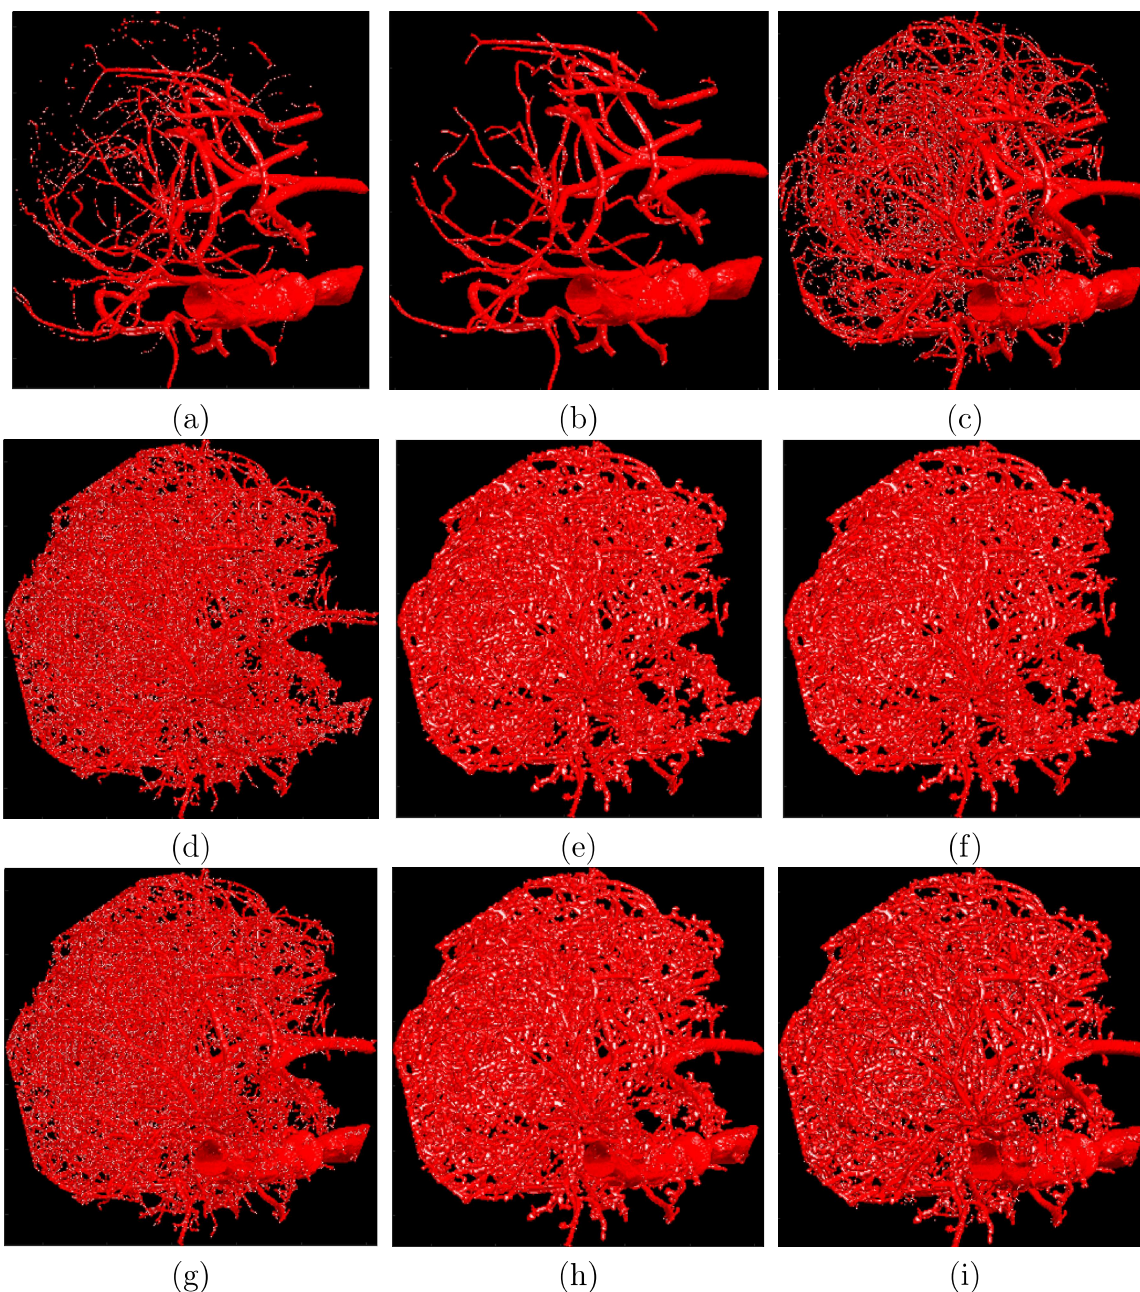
Visual comparison of the three developed hybrid segmentation methods on CT scan images. (a) medium to big vessels using multi-threshold Otsu method; (b) medium to big vessels using multi-threshold Otsu method combined with hysteresis thresholding; (c) medium to big vessels using hysteresis thresholding; (d) small to medium vessels using WHVEF in [37]; (e) and (f) small to medium vessels using WBHVEF in [35]; (g) whole vessel tree after adding the image using multi-threshold Otsu and image using WHVEF [37]; (h) whole vessel tree after adding the image using multi-threshold Otsu with hysteresis and image using WBHVEF [35]; (i) whole vessel tree after adding the image using hysteresis and image using WBHVEF.
